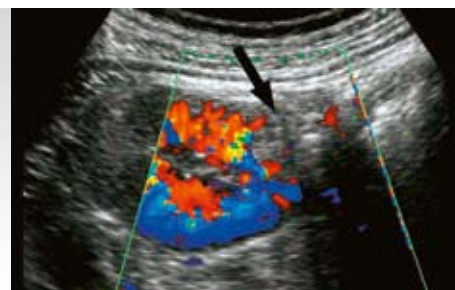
b: At color Doppler US, the lesion appeared poorly vascular compared to the adjacent cortex.
